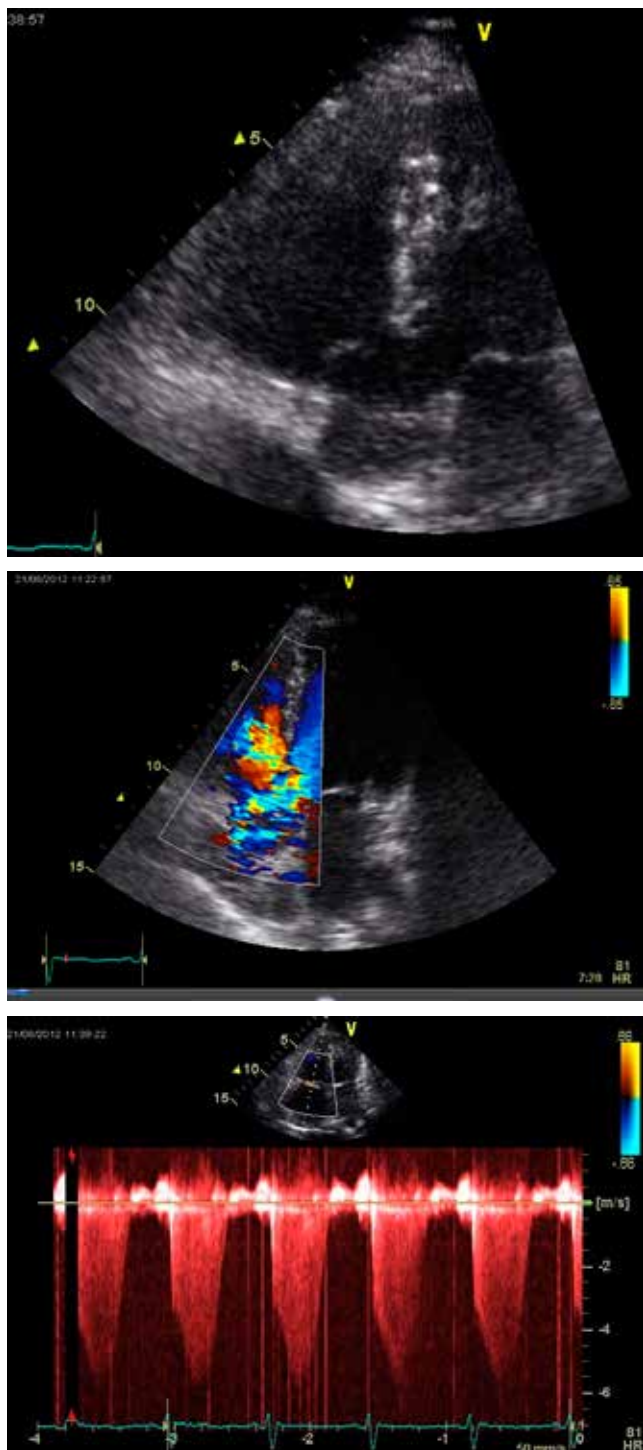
Transthoracic echocardiogram during treatment showed a ventricular septal defect (A), moderate tricuspid regurgitation (B) and severe pulmonary hypertension (C)
